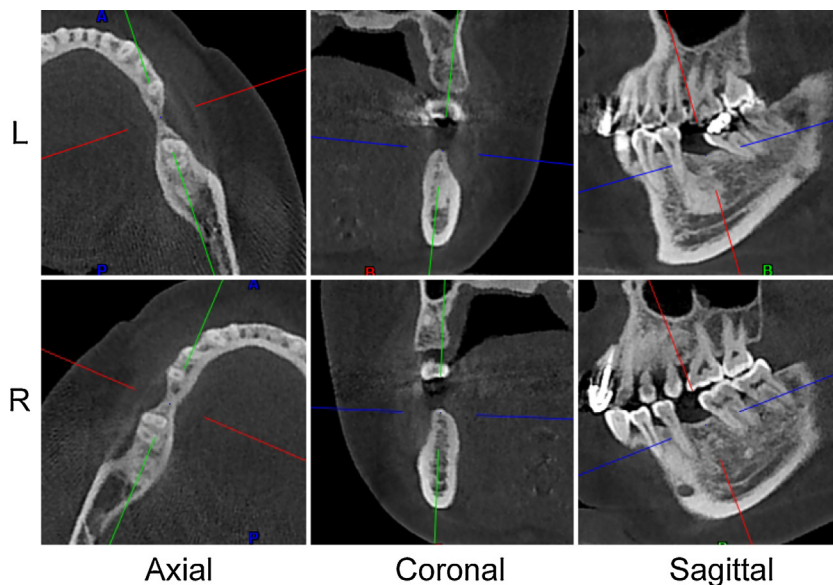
Preoperative CBCT scan.
